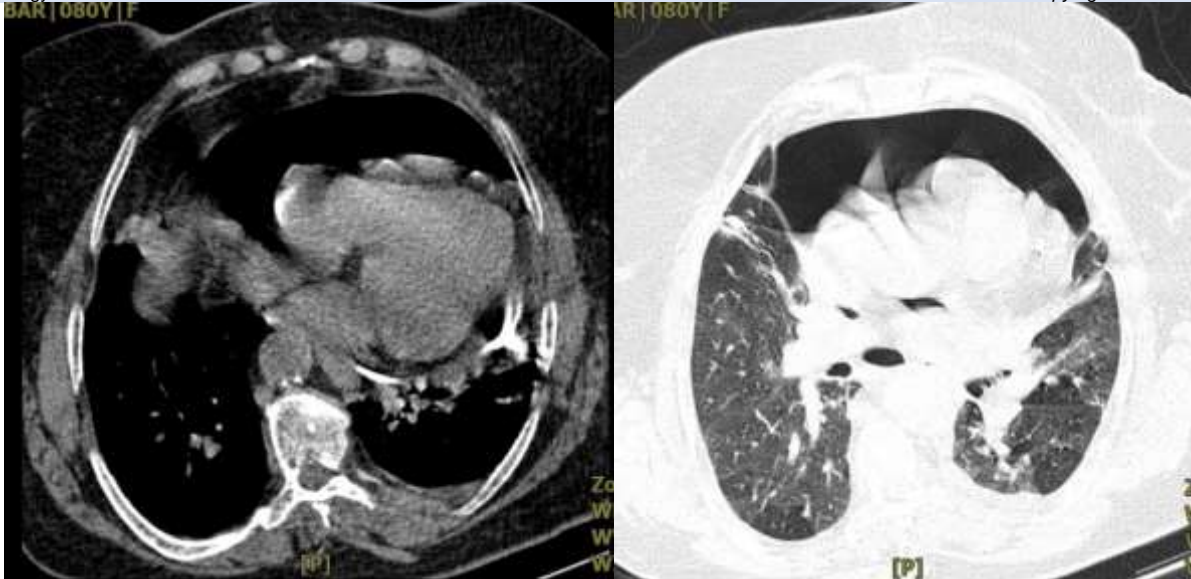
Lung CT scan the following day of pericardiocentesis which shows air collection in mediastinum and pericardial space
